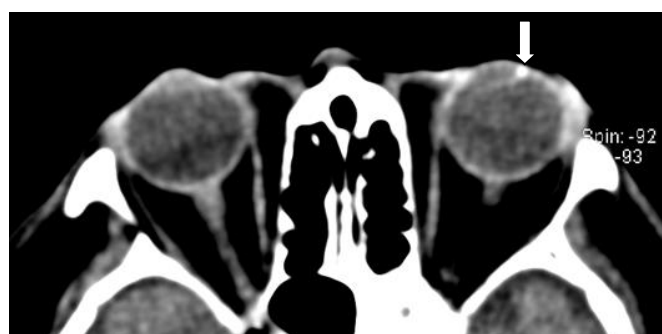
CT Scan of the orbit showed a round radio opaque foreign body at the lateral aspect of the left intraocular lens, measuring approximately 0.3cm (white arrow)
